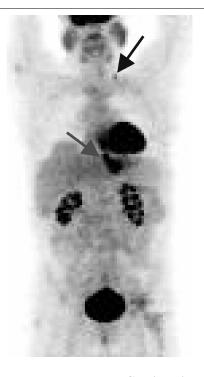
PET scan shows FDG avid primary distal esophageal adenocarcinoma (red arrow). Uptake within a left supraclavicular lymph node (black arrow) represents a distant lymph node metastasis, indicating unresectable disease.
